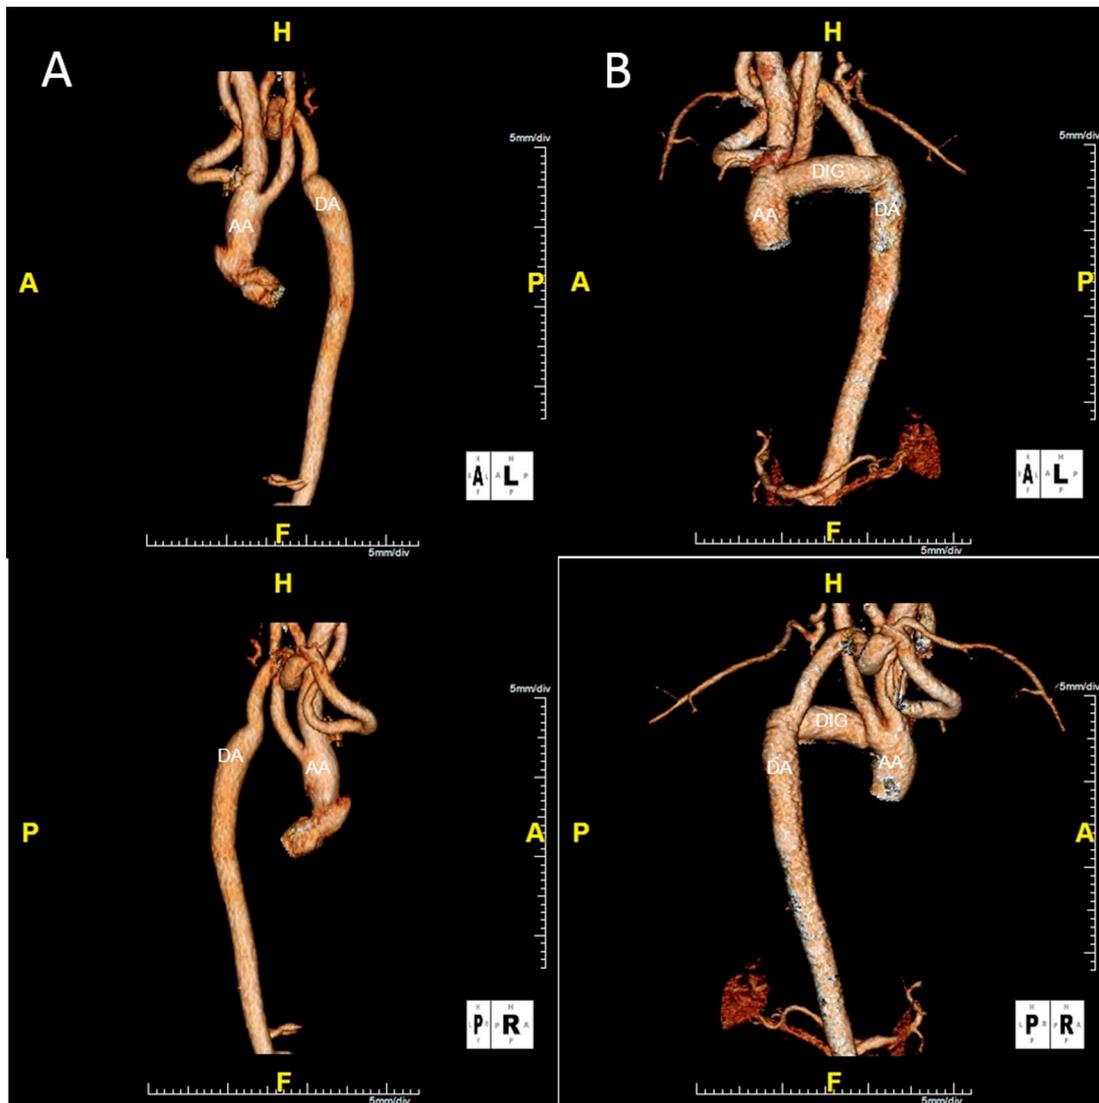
Images depict 3D volume rendered CT angiography of type B IAA without a PDA before (A) and after (B) surgical repair. DIG = Dacron interposition graft; AA = ascending aorta; DA = descending aorta.
